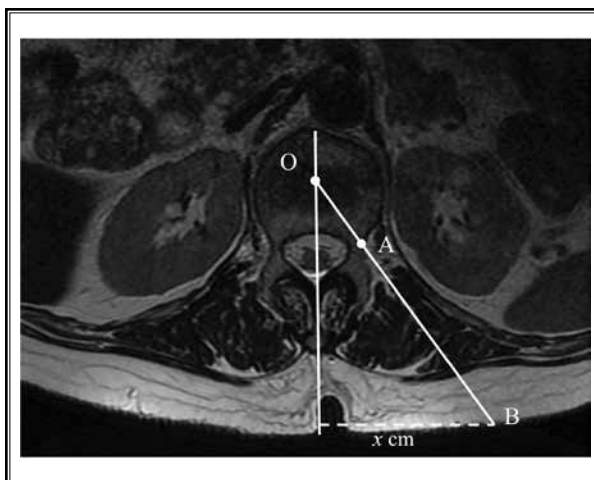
The puncture trajectory and skin puncture point of modified unilateral extrapedicular PKP were determined from preoperative axial MRI or CT. Point O was the center point of VB, and Point A was the center point of VB, located in the superolateral junction between the pedicle and VB. The intersection of Line OA and the surface of skin was Point B. Line BO was the puncture trajectory and Point B was skin puncture point. Then, the distance of Point B to midline (x cm) and the angle between Line BO and midline were measured. PKP, percutaneous kyphoplasty; MRI, magnetic resonance imaging; CT, computed tomography; VB, vertebral body.
